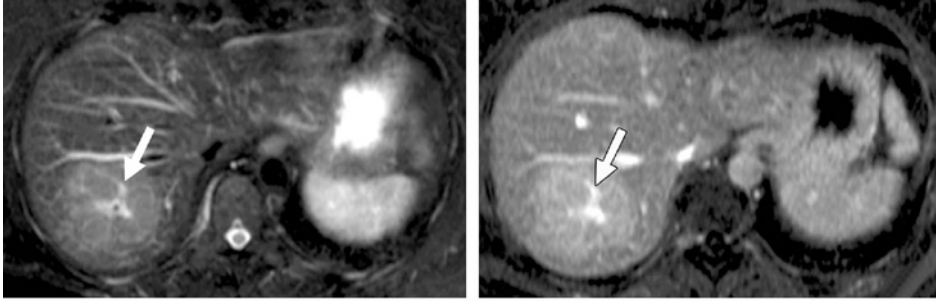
MR imaging appearance of an FNH lesion with a prominent central scar. a. Axial fat-saturated T2-weighted fast SE image shows a large FNH lesion with a prominent central scar (arrow), which has high signal intensity. A pseudocapsule is not visible. b. Axial gadolinium-enhanced fat-saturated 2D T1-weighted GRE image obtained during the delayed phase shows that the lesion has become isointense relative to the liver and the central scar has enhanced (arrow).
